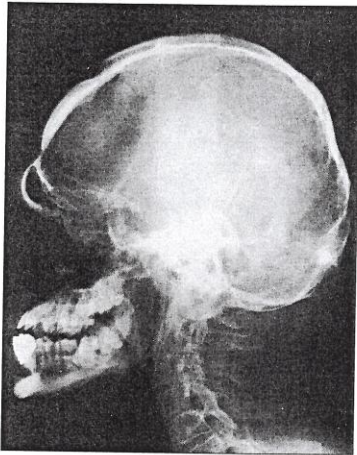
Lateral cephalometric radiograph of the patient. Brachycephaly, short anterior and posterior cranial base, concave profile, short facial height, multiple radiolucencies in occiput, along the frontal craniotomy line and spinous vertebral processes, fusion of superior vertebrae.
